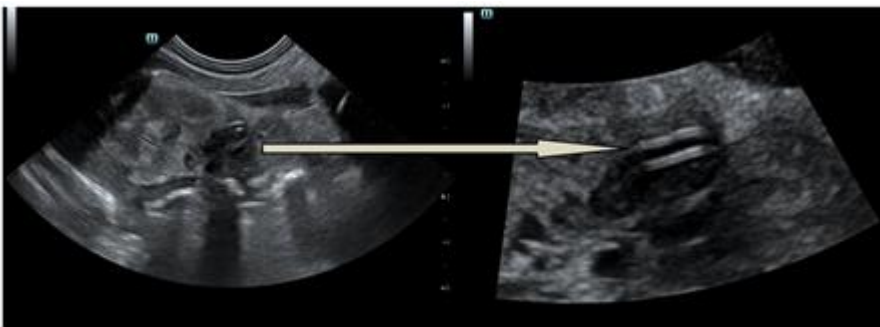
3-day old girl born vaginally with pigtail shunt inserted at the 27th of gestational age because of unilateral hydronephrosis of left kidney with 23mm pelvic in diameter. Ultrasound scan shows left kidney with patent shunt inserted in kidney. No dilatation of renal pelvis was seen at the neonatal period. Shadow seen beneath the shunt.
